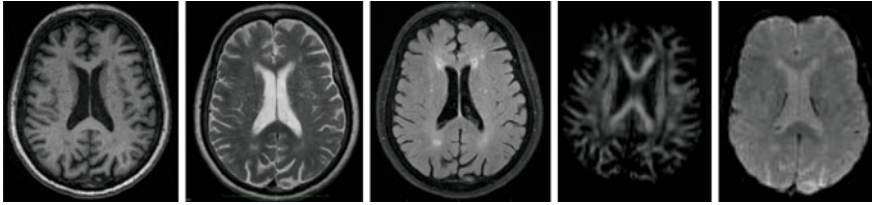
T1, T2, FLAIR, DTI, and T2* images from 3T scanner
